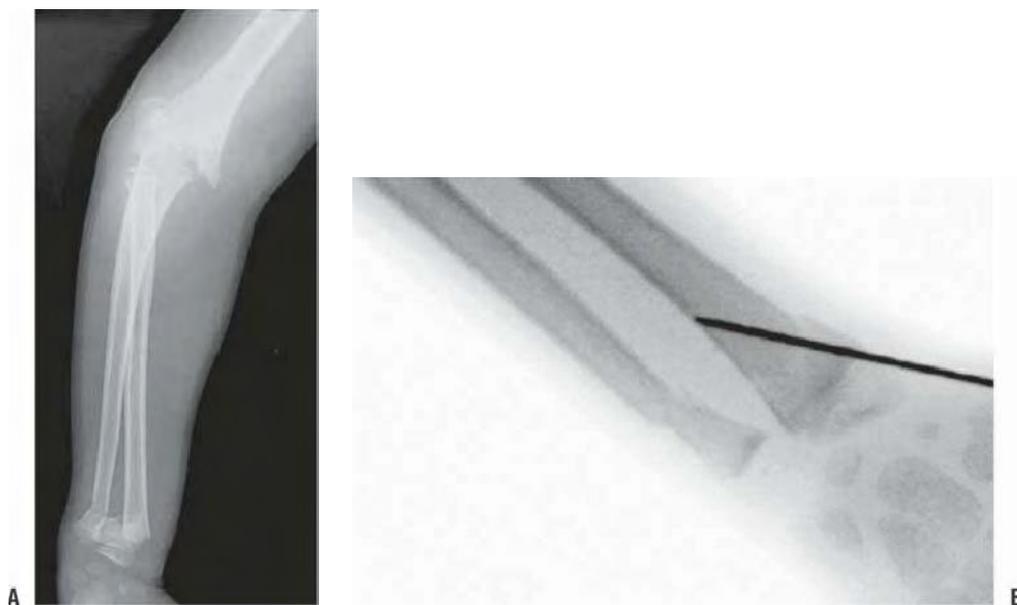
Fixation of a distal radius fracture with an ipsilateral supracondylar fracture. A: This AP radiograph of the forearm and elbow of a 6-year-old boy shows a completely displaced distal radius fracture and a type III supracondylar humerus fracture. The arm was swollen and the hand was perfused, but the radial pulse could not be palpated. Because of the risk of forearm compartment syndrome, the surgeon elected to do closed pinning of both the supracondylar fracture and the distal radius fracture. B: Intraoperative image after K-wire fixation was used for the distal radius fracture. After pinning, the arm and elbow were splinted with the elbow in 30 degrees of flexion.
